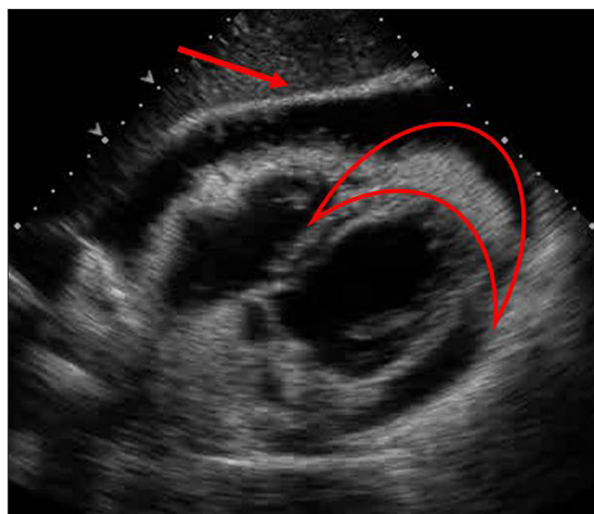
Echocardiographic density suggesting fibrinous material over the epicardium (crescent) and a thickened pericardium (arrow).
